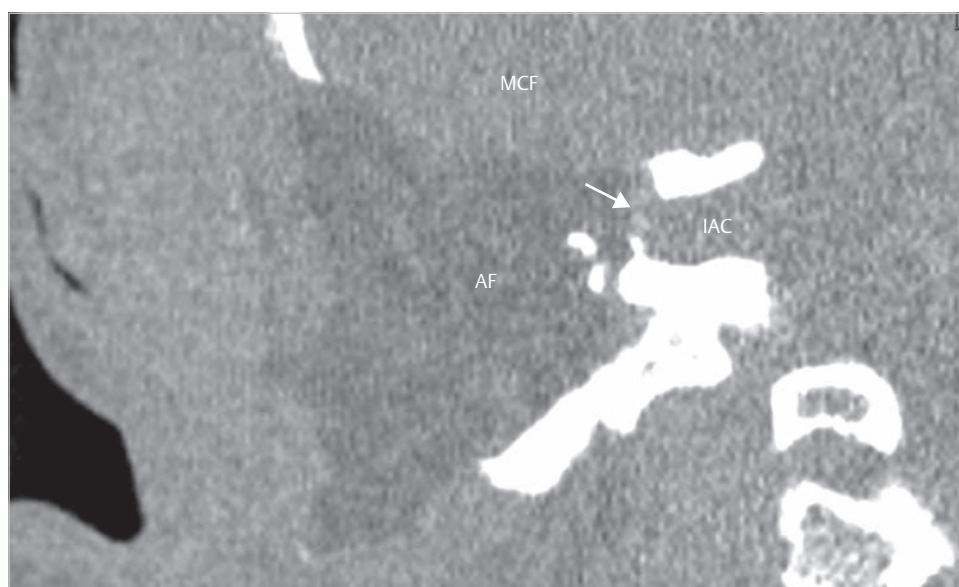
The postoperative coronal CT demonstrates extensive exposure of the middle fossa dura and opening of the internal auditory canal at the fundus (*arrow*). AF, abdominal fat; IAC, internal auditory canal; MCF, middle cranial fossa.
